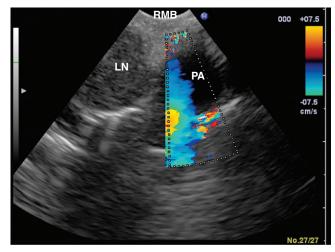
EBUS image of intrapulmonary node (LN) on the right detected from the right upper lobe carina (station 11R). The Doppler signal demonstrates a branch from the pulmonary artery (PA). RMB, position of the scope in the right main bronchus.
